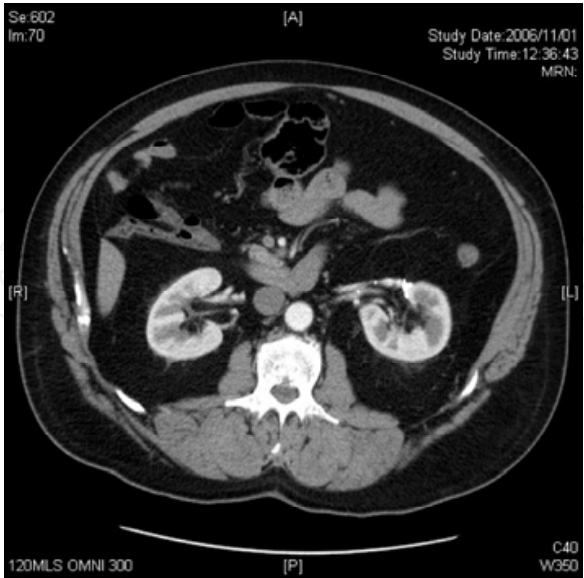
Follow-up abdominal CT scan performed 30 months postoperatively, confirming resolution of the aneurysm and prompt arterial flow to the left kidney
